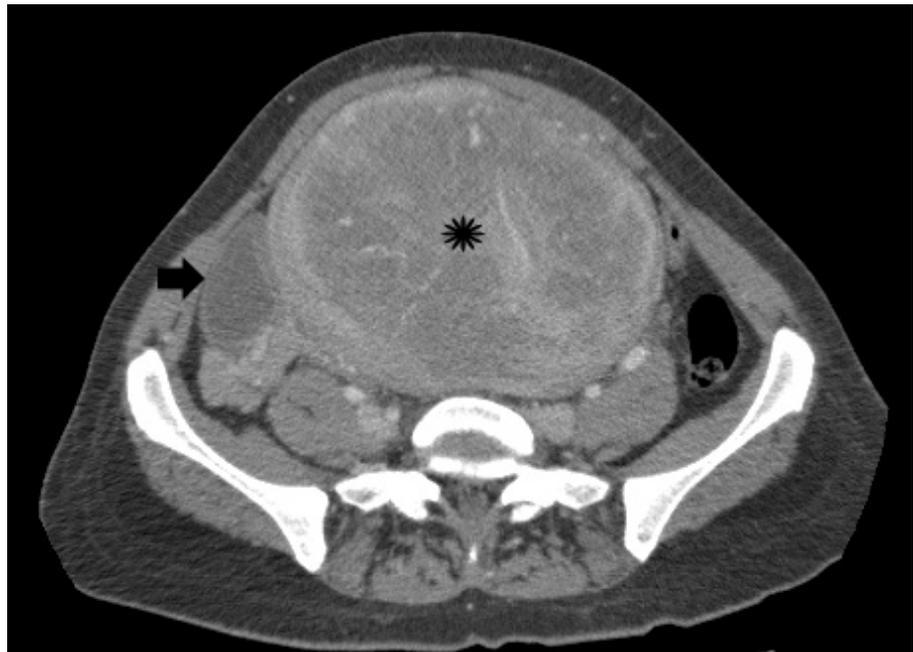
CT of uterine leiomyoma. Contrast-enhanced CT of the pelvis in a 39-year-old woman with a known uterine leiomyoma shows a large oval mass within the uterus with heterogeneous enhancement (*asterisk*) which displaces the hypodense right ovary (*arrow*) and distends the abdomen
